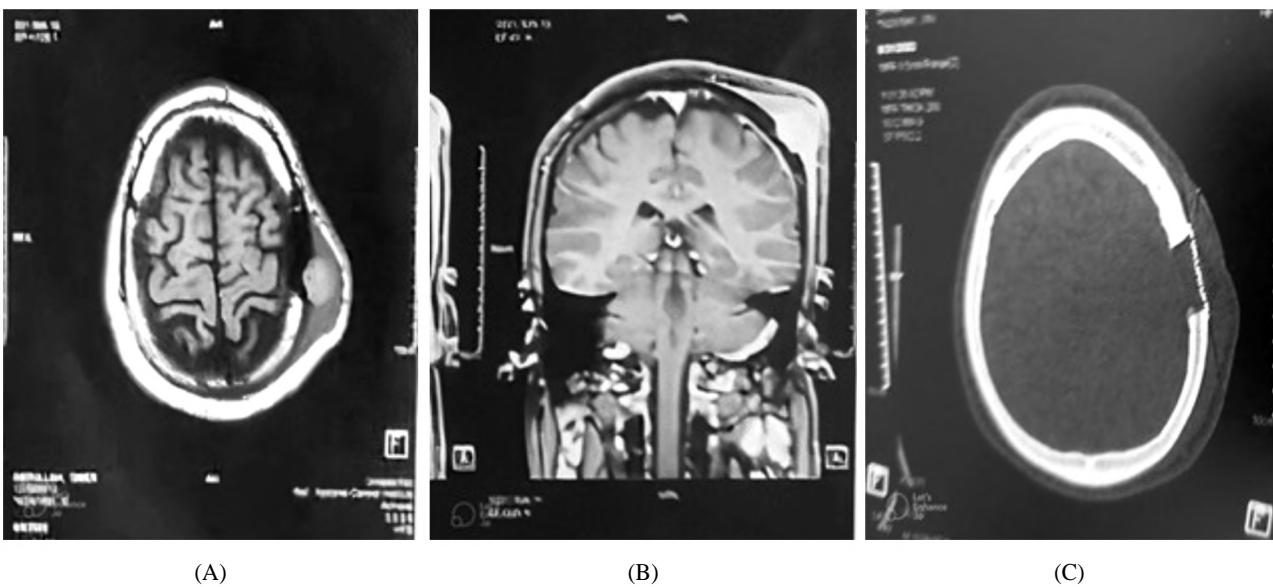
Preoperative MRI brain with contrast (A: Coronal view, B: Axial view) showing left parietal lesion with subgaleal soft tissue mass with erosion and sclerosis of underlying calvarial bone. (C: Axial view): Post-operative CT scan, bone window showing post excision with plate reconstruction.
